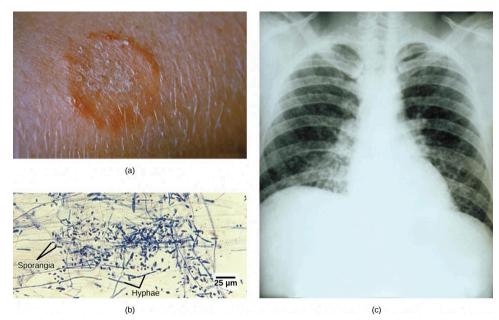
(a) Ringworm presents as a red ring on the skin. (b) Trichophyton violaceum is a fungus that causes superficial mycoses on the scalp. (c) Histoplasma capsulatum, seen in this X-ray as speckling of light areas in the lung, is a species of Ascomycota that infects airways and causes symptoms similar to the flu. (credit a, b: modification of work by Dr. Lucille K. Georg, CDC; credit c: modification of work by M Renz, CDC; scale-bar data from Matt Russell)
